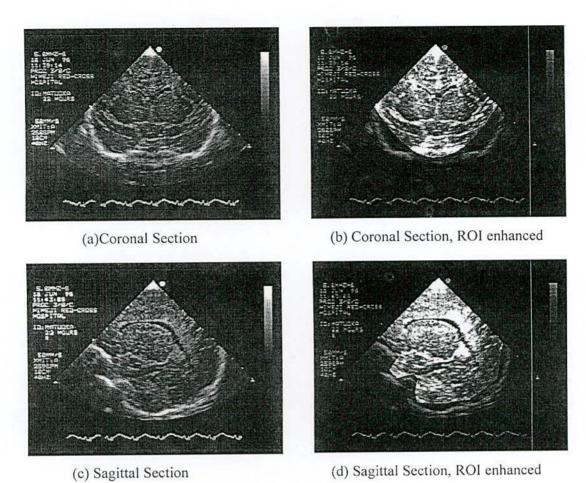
Original Ultrasonographic images of coronal and sagittal sections with mask inside the cranial bone. Regions of interest (ROI) are shown as bright region in the images (b) and (d)
